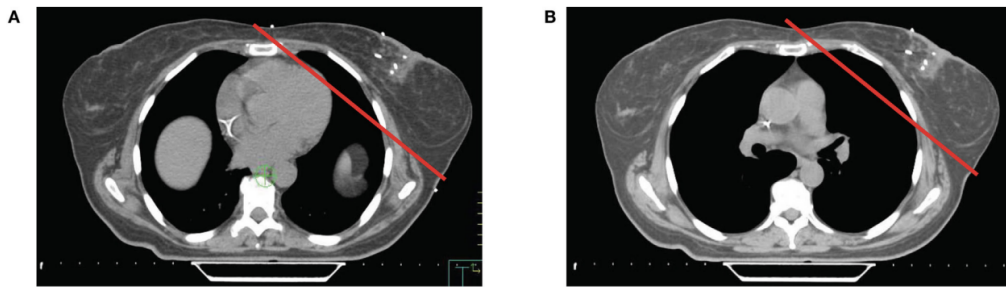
Axial CT slices from the same level of the breast in [A] free breathing and [B] DIBH CT scans [20].
